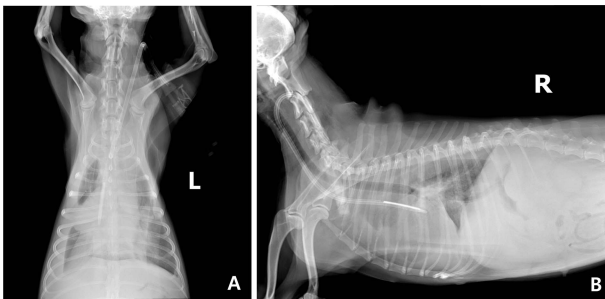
Thoracic radiographs. Pleural effusion is observed in the VD (A), and lateral view (B).
